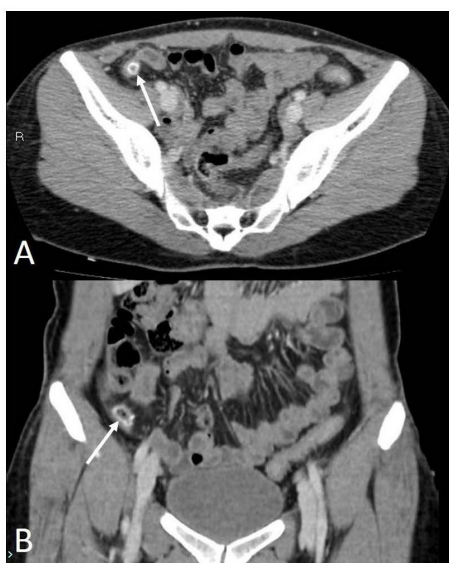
A) Axial and B) coronal CT images of the pelvis which were obtained at the time of clinical presentation.
